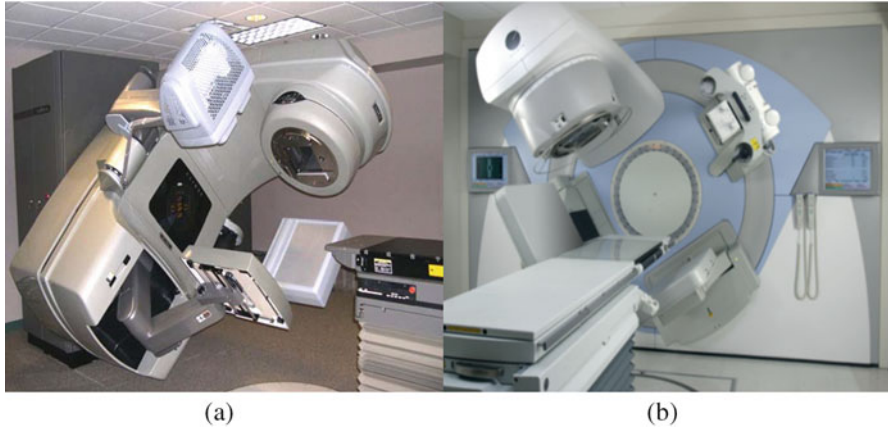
(a) Varian TrueBeam accelerator (Varian Oncology Systems, Palo Alto, CA). (b) Elekta Synergy (Elekta Inc.). Both accelerators are equipped with kilovoltage imaging systems capable of 2D planar radiography, fluoroscope, and cone beam CT modes
